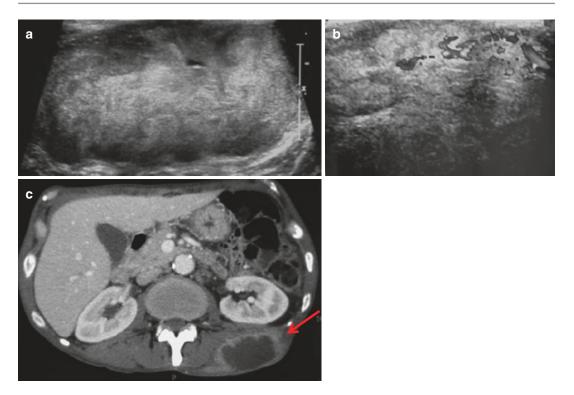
Intramuscular metastases. (a) Gray-scale and (b) color Doppler 12–5 MHz US images in patient with previously diagnosed malignancy (lung adenocarcinoma): well-defined lobulated shape hypoechoic nodules located
